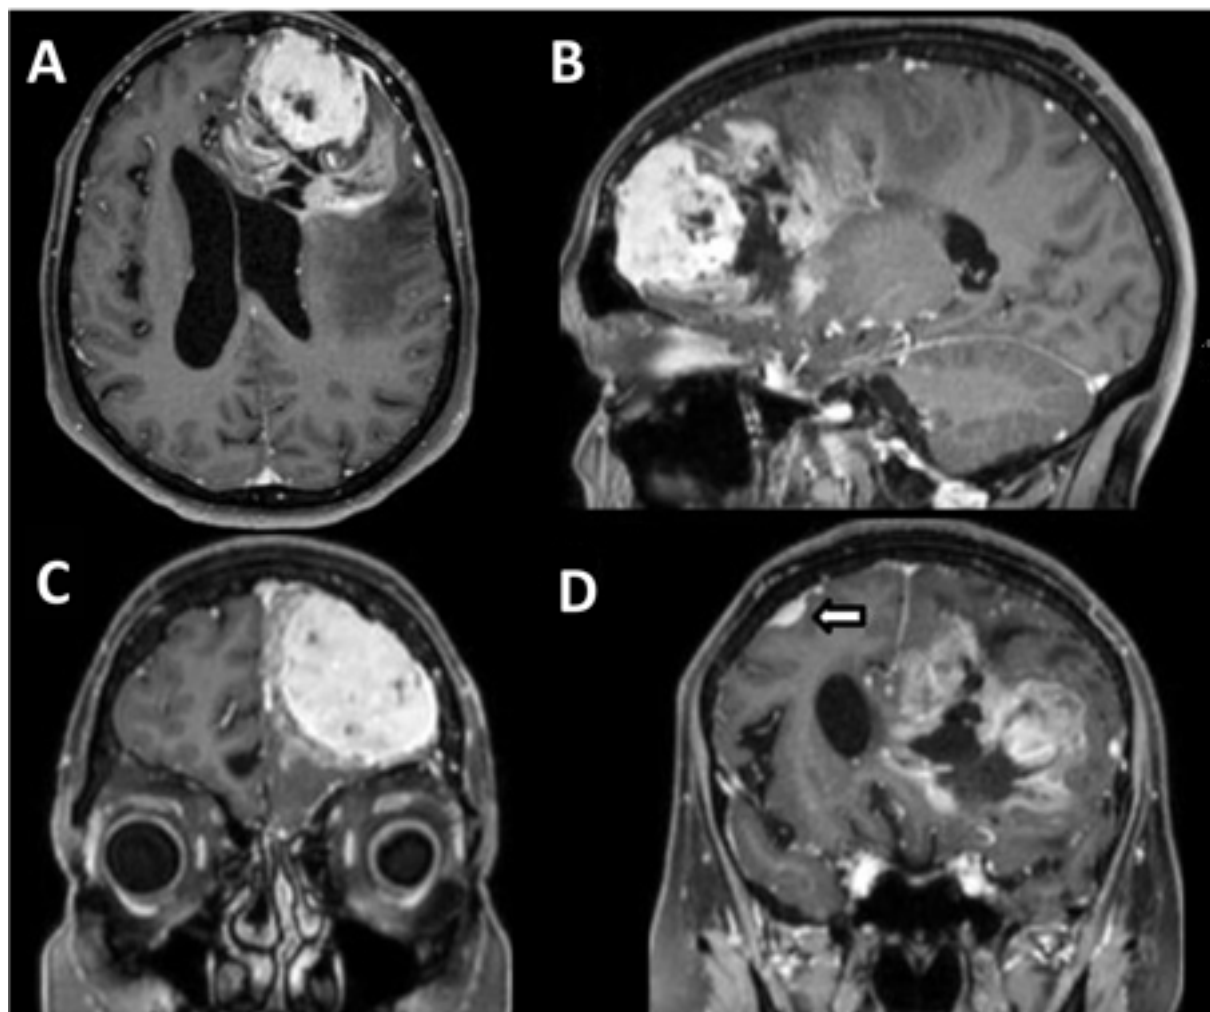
T1-weighted MRI of the skull with gadolinium. A. axial section, B. sagittal section, showing an expansive lesion on the left front with an extra-axial component with a dural tail and homogeneous contrast enhancement, and around it, showing an intra-axial, infiltrative lesion with heterogeneous contrast enhancement. C. coronal section showing an expansive lesion with homogeneous contrast enhancement. D. coronal section showing an expansive, heterogeneous and infiltrative lesion on the left and a small contralateral extra-axial lesion with homogeneous contrast enhancement, compatible with a convexity meningioma (arrow).
